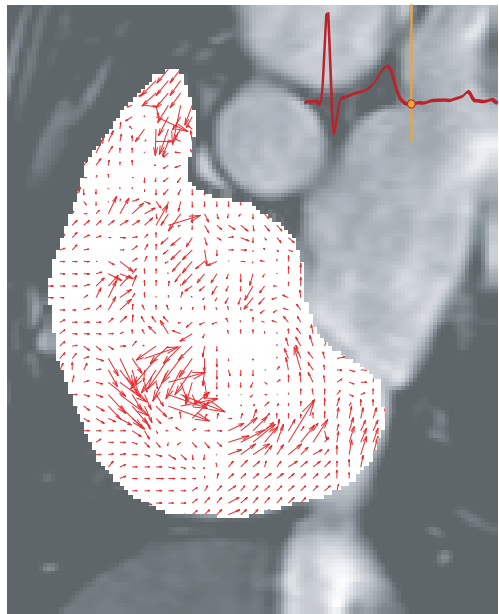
MRI Scans of right atrial flow pre- and post-ASO. One slice that passes through the septal defect has been chosen for flow analysis here. The size of the pre-ASO atrium is shown to be larger than that of the post-ASO one. It can be deduced from this scans that there is an inbalance of pressure maintained by both atria. In this case, pressure is increased in the right atrium due to the left to right shunting of blood that causes the blood circulation in the heart to lose efficiency.
